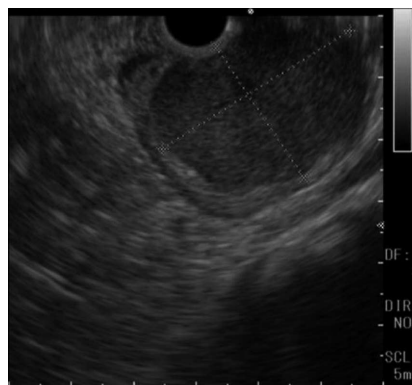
Findings on upper endoscopic ultrasonography. A homogeneous, hypoechoic, well-demarcated mass, approximately 4 cm in diameter with a flat border, arising from the fourth layer of the gastric wall.
